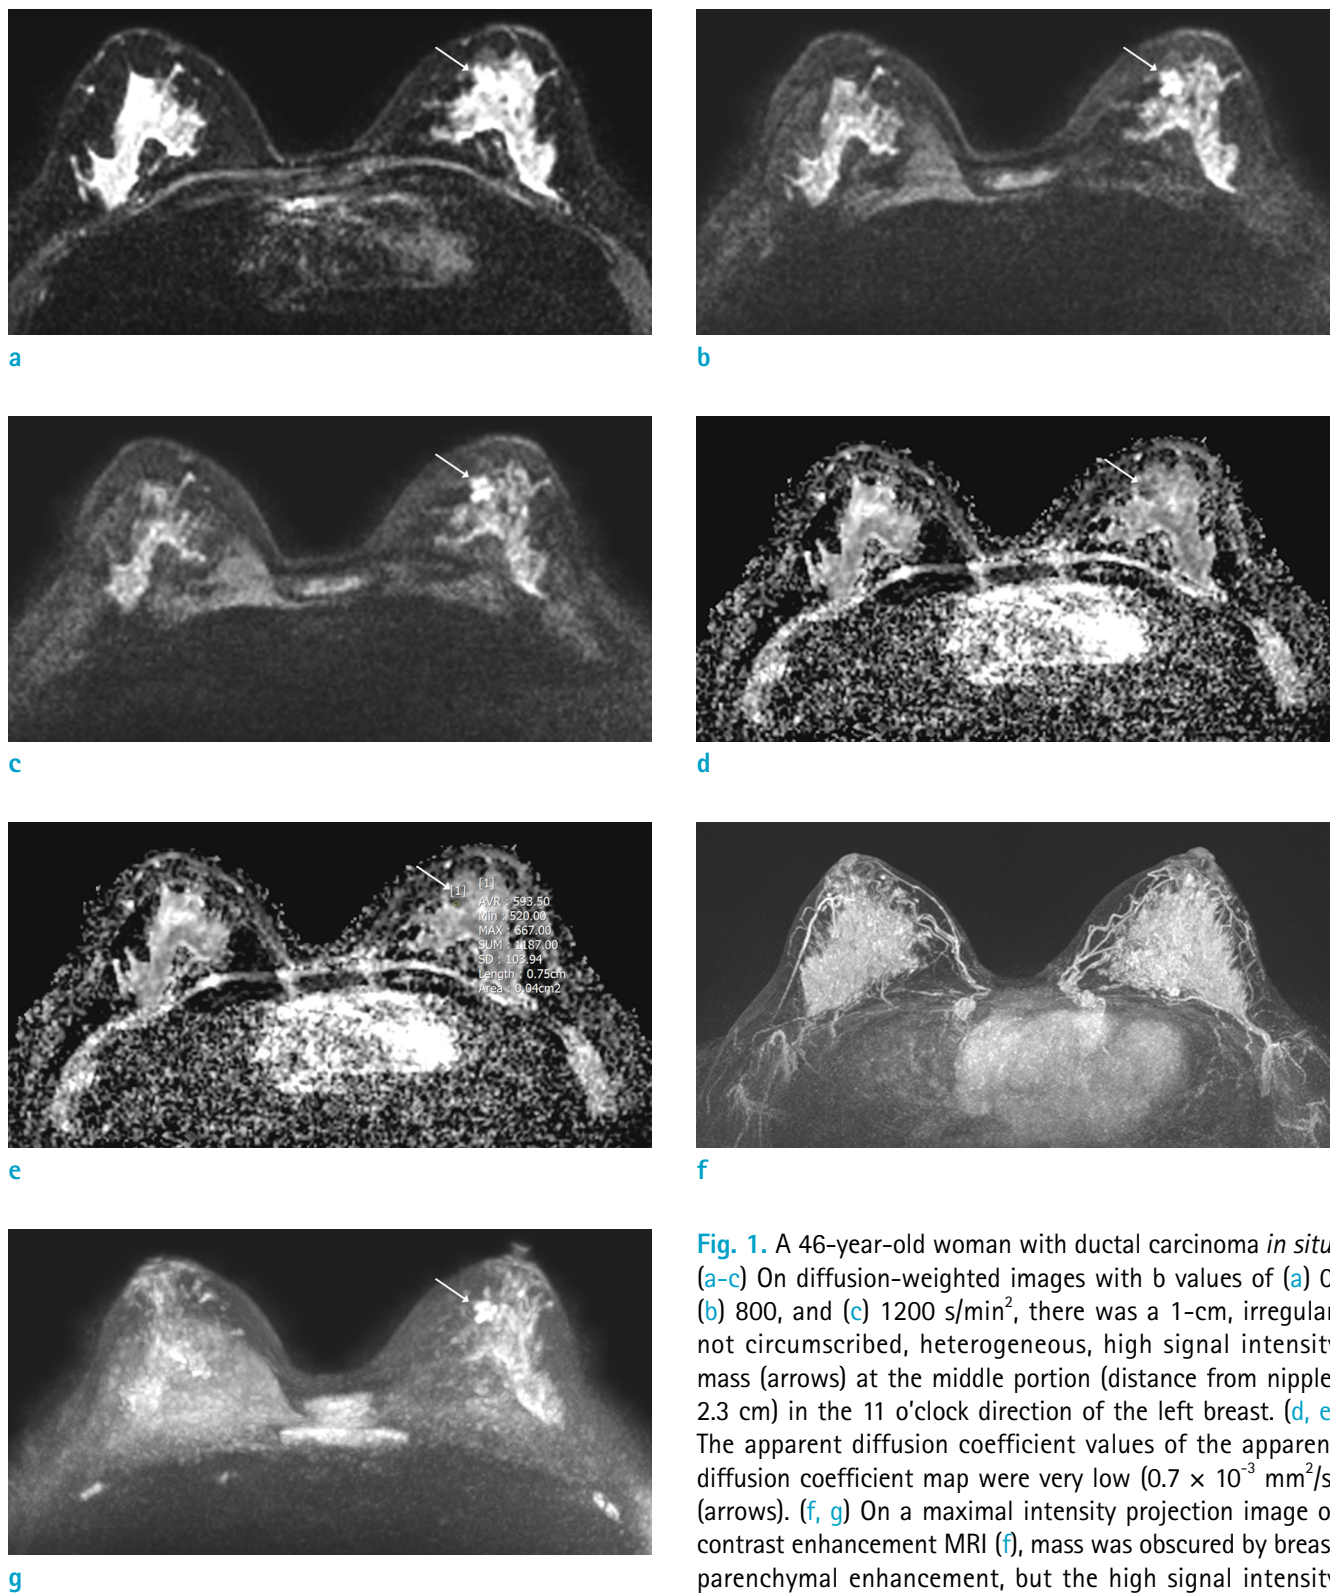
A 46-year-old woman with ductal carcinoma *in situ*. (a–c) On diffusion-weighted images with b values of (a) 0, (b) 800, and (c) 1200 s/min², there was a 1-cm, irregular, not circumscribed, heterogeneous, high signal intensity mass (arrows) at the middle portion (distance from nipple: 2.3 cm) in the 11 o'clock direction of the left breast. (d, e) The apparent diffusion coefficient values of the apparent diffusion coefficient map were very low ($0.7 \times 10^{-3} \text{ mm}^2/\text{s}$) (arrows). (f, g) On a maximal intensity projection image of contrast enhancement MRI (f), mass was obscured by breast parenchymal enhancement, but the high signal intensity mass was prominent on a diffusion maximal intensity projection image (arrow) (g).
